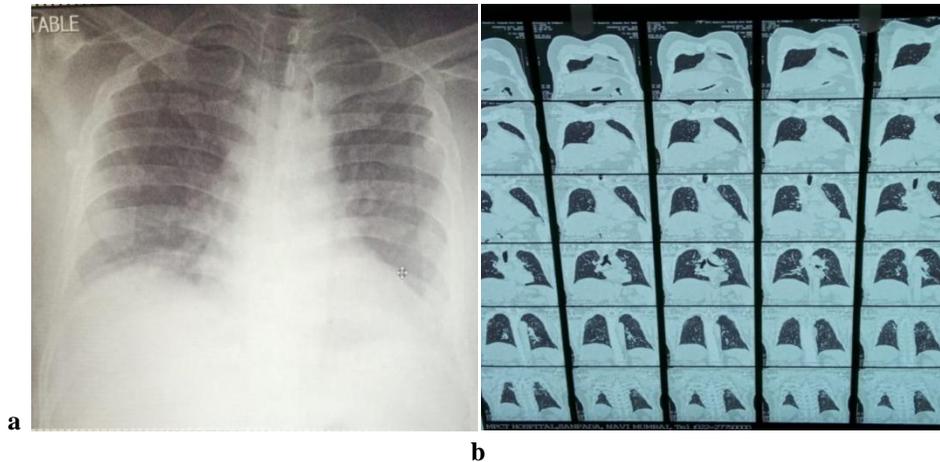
(a) chest X ray and (b)HRCT chest was done which showed pneumonia pattern in the peripheral and basal region
